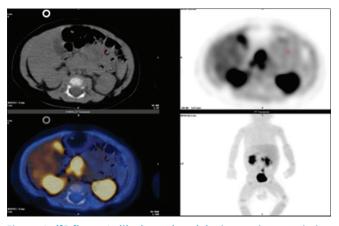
¹⁸F-fluoro-L-dihydroxyphenylalanine positron emission tomography/computed tomography scan images of focal congenital hyperinsulinism. Increased maximum standardized uptake value (6.67) confirms focal uptake of ¹⁸F-fluoro-L-dihydroxyphenylalanine in the head of the pancreas
